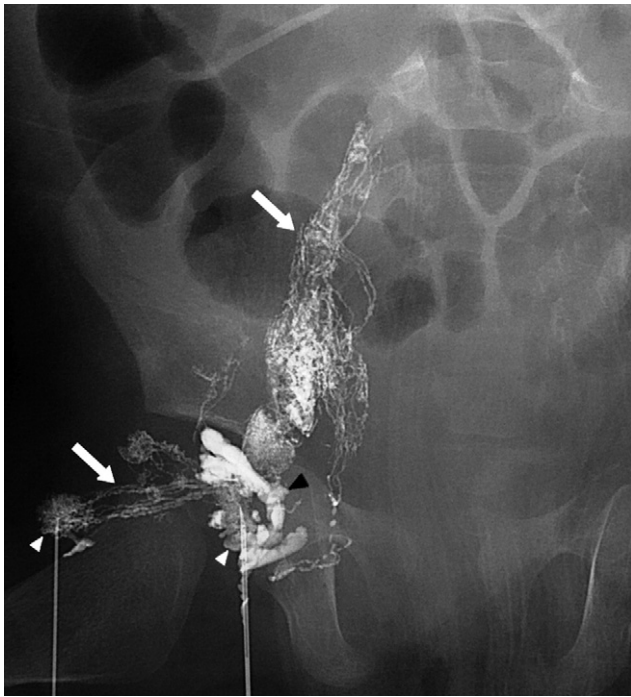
Spot radiograph of right groin in patient 3 shows opacification of two lymph nodes (white arrowheads) with extravasation (black arrowhead). There is also opacification of normal femoral and iliac efferent lymphatic channels (arrows).
